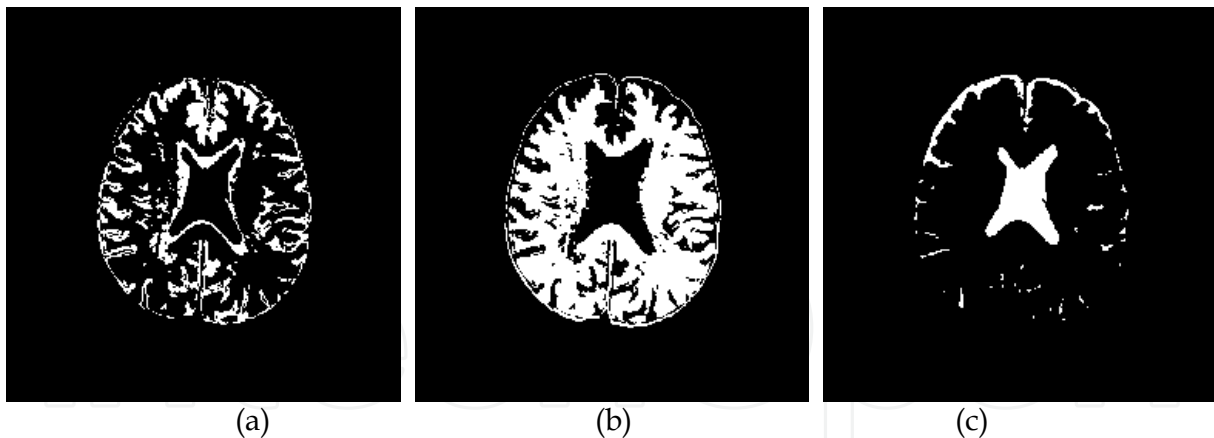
Real Classification result of brain MR images by UVSRG. (a)GM (b)WM (c)CSF
